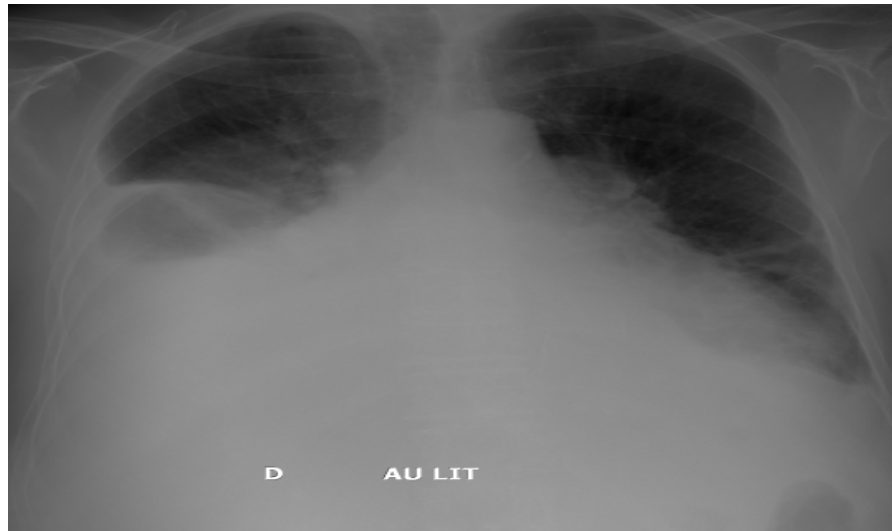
Chest: X-ray predominantly right pleural effusion and an enlarged cardiac silhouette.
